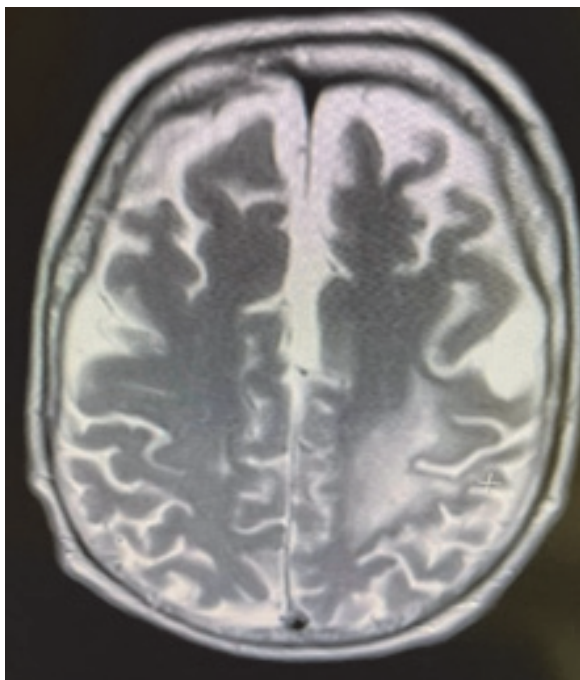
Brain MRI showing symmetrical bilateral perifrontal and perisylvic cortical volume loss.
